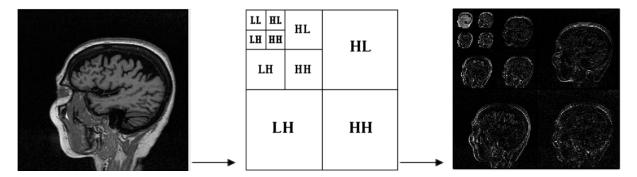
The LL is an approximation to the three-level decomposition of DWT of T1-weighted MRI images based on the Haar basis function
